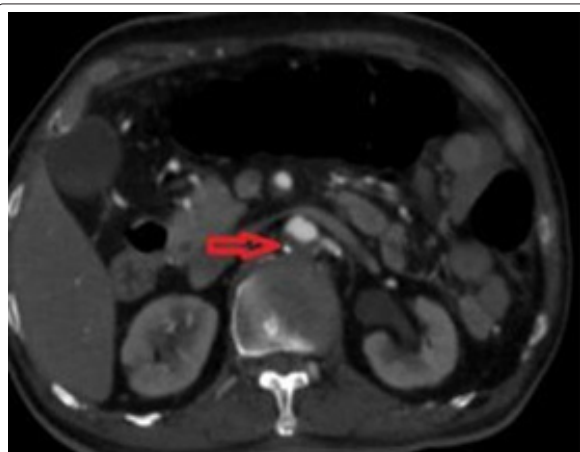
CT abdomen, axial section showing thrombosis in suprarenal aorta (arrow-red).
